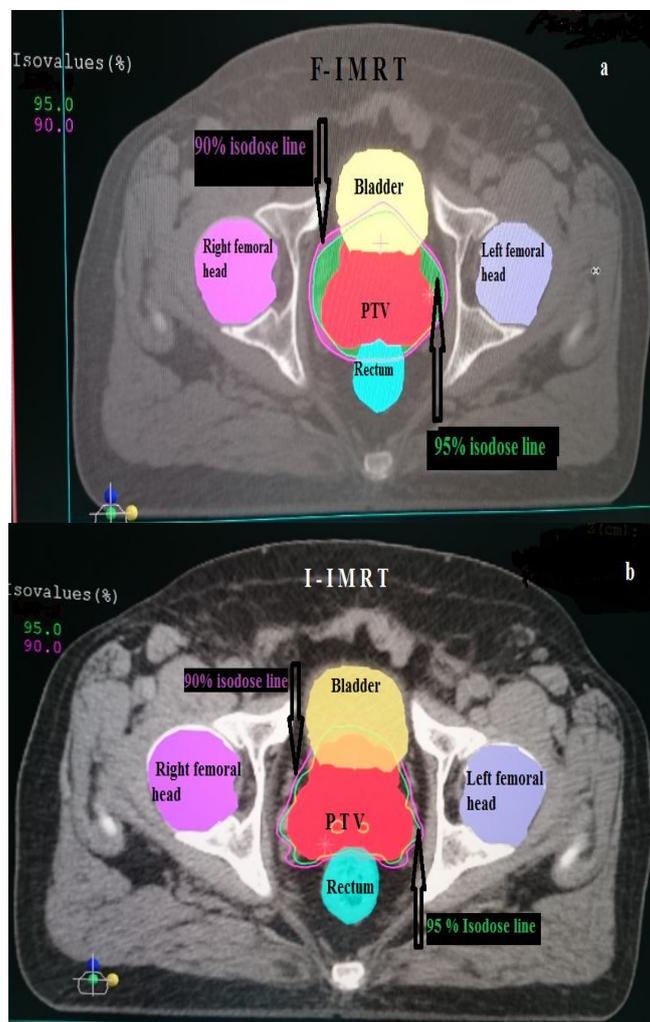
the isodose distribution in the transverse CT section (a) F-IMRT and (b) I-IMRT plans.
